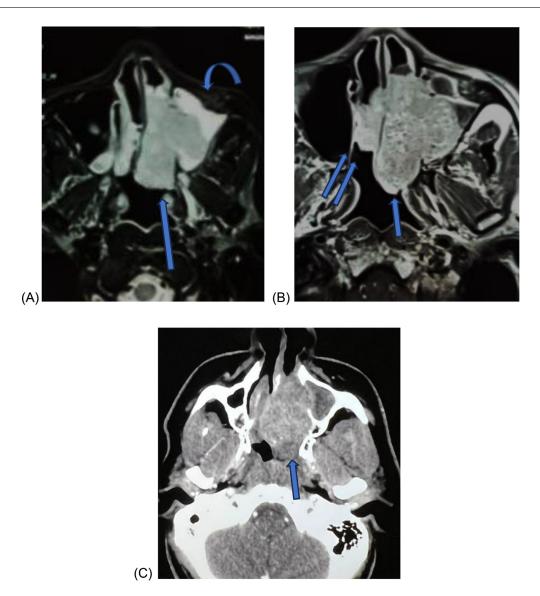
MRI and CT of the facial: axial T2-weighted sections with fat suppression (A), T1-weighted images with fat suppression and gadolinium injection (B), and axial CT section after injection: Left endonasal mass in T2 hypersignal and intensely enhanced after injection (short arrow), extending towards the nasopharynx and with a maxillary intrasinus component. Note the inflammatory retention in the left maxillary sinus (curved arrow) and the extension to the right nasal cavity (double arrow).
